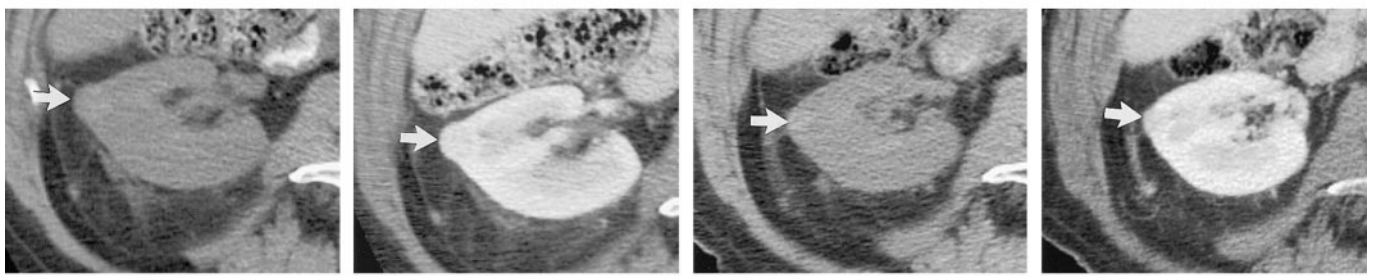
Patient 2. Small exophytic renal cell carcinoma in an 81-year-old man. (a) Preablation transverse CT scans without (left) and with (right) intravenous contrast material show a 1.2-cm enhancing, biopsy-proved renal cell carcinoma (arrows) arising in the right kidney. This tumor had an attenuation value of 109 HU. (b) Transverse CT scans obtained at the same level as in a without (left) and with (right) contrast enhancement, 6 months after RF ablation, show a decrease in the size of the renal cell carcinoma (arrows). The residual tumor is no longer enhancing.
